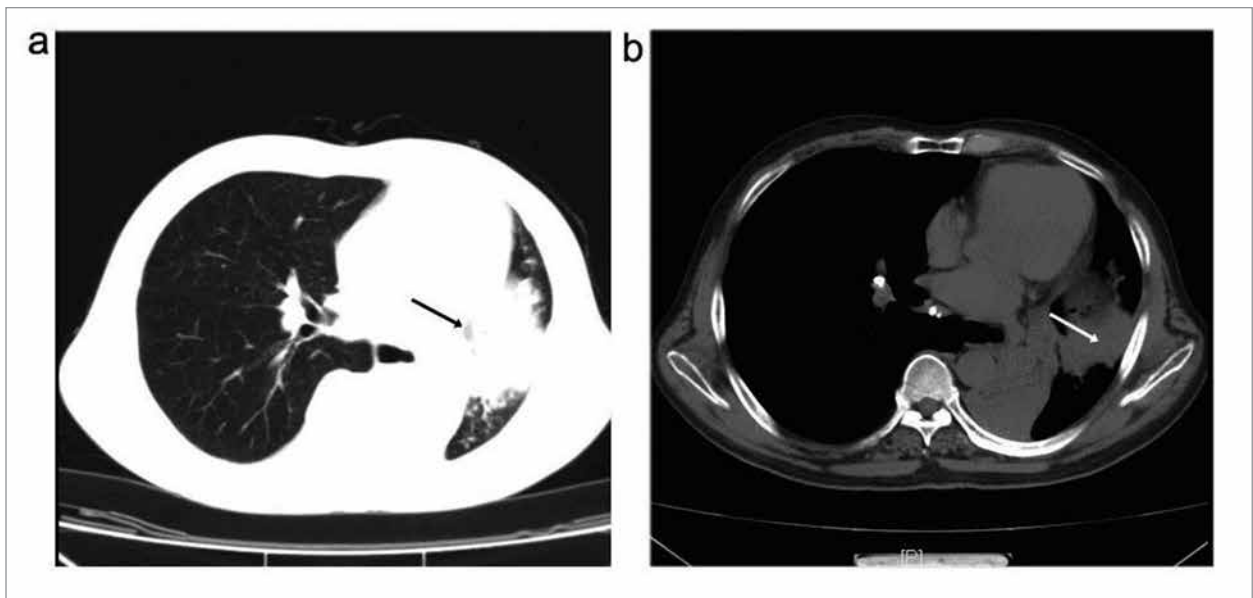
Chest CT scan, showing atelectasis in the left lower lobe, occlusion of the left main bronchus, multiplicity of the mediastinum, and swollen and partially calcified lymph nodes
